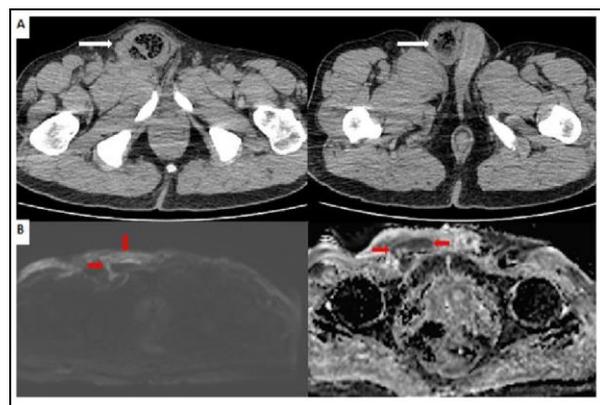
A. 60-year-old man with swelling and pain in the right inguinal region. A. Axial computed tomography shows right inguinal hernia (white arrow). B. Diffusion-weighted MRI ($b=1000\text{ s/mm}^2$) and apparent diffusion coefficient map shows diffusion restriction compatible with strangulation (red arrow).
